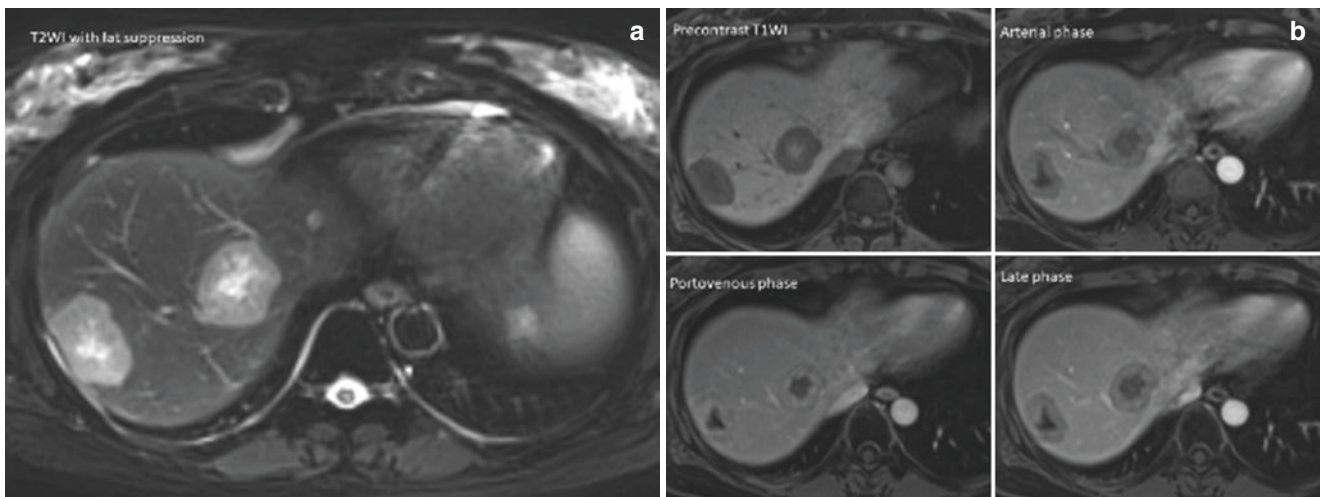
A 46-year-old female with breast carcinoma and multiple liver metastases underwent Gd-DTPA-enhanced MR imaging. (a) The tumor is hyperintense on T2WI. (b) The tumor features hypointense on
